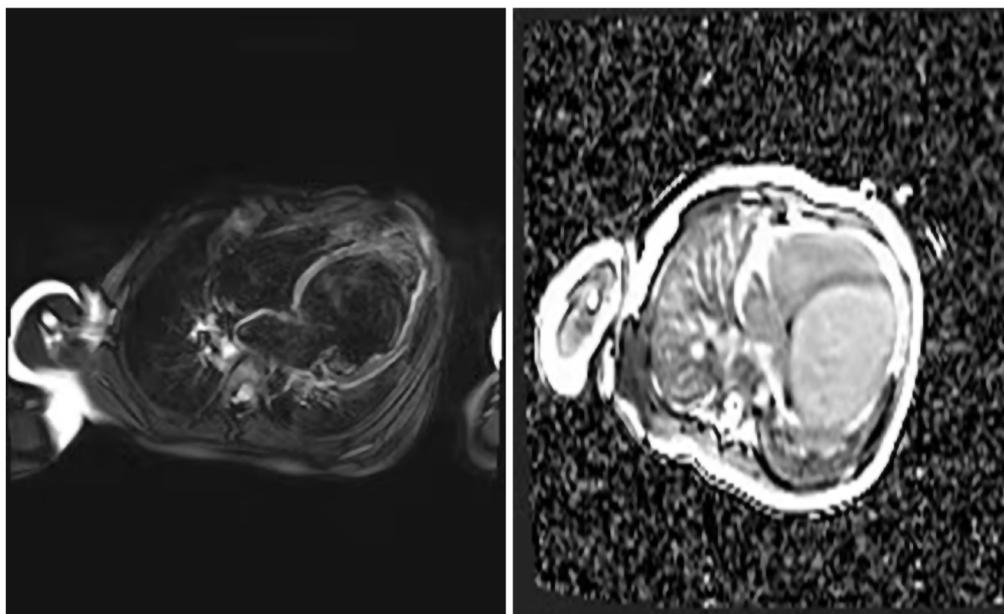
Magnetic resonance images. Cardiac magnetic resonance imaging showed enlarged ventricles, reduced systolic function, and focal delayed enhancement.
